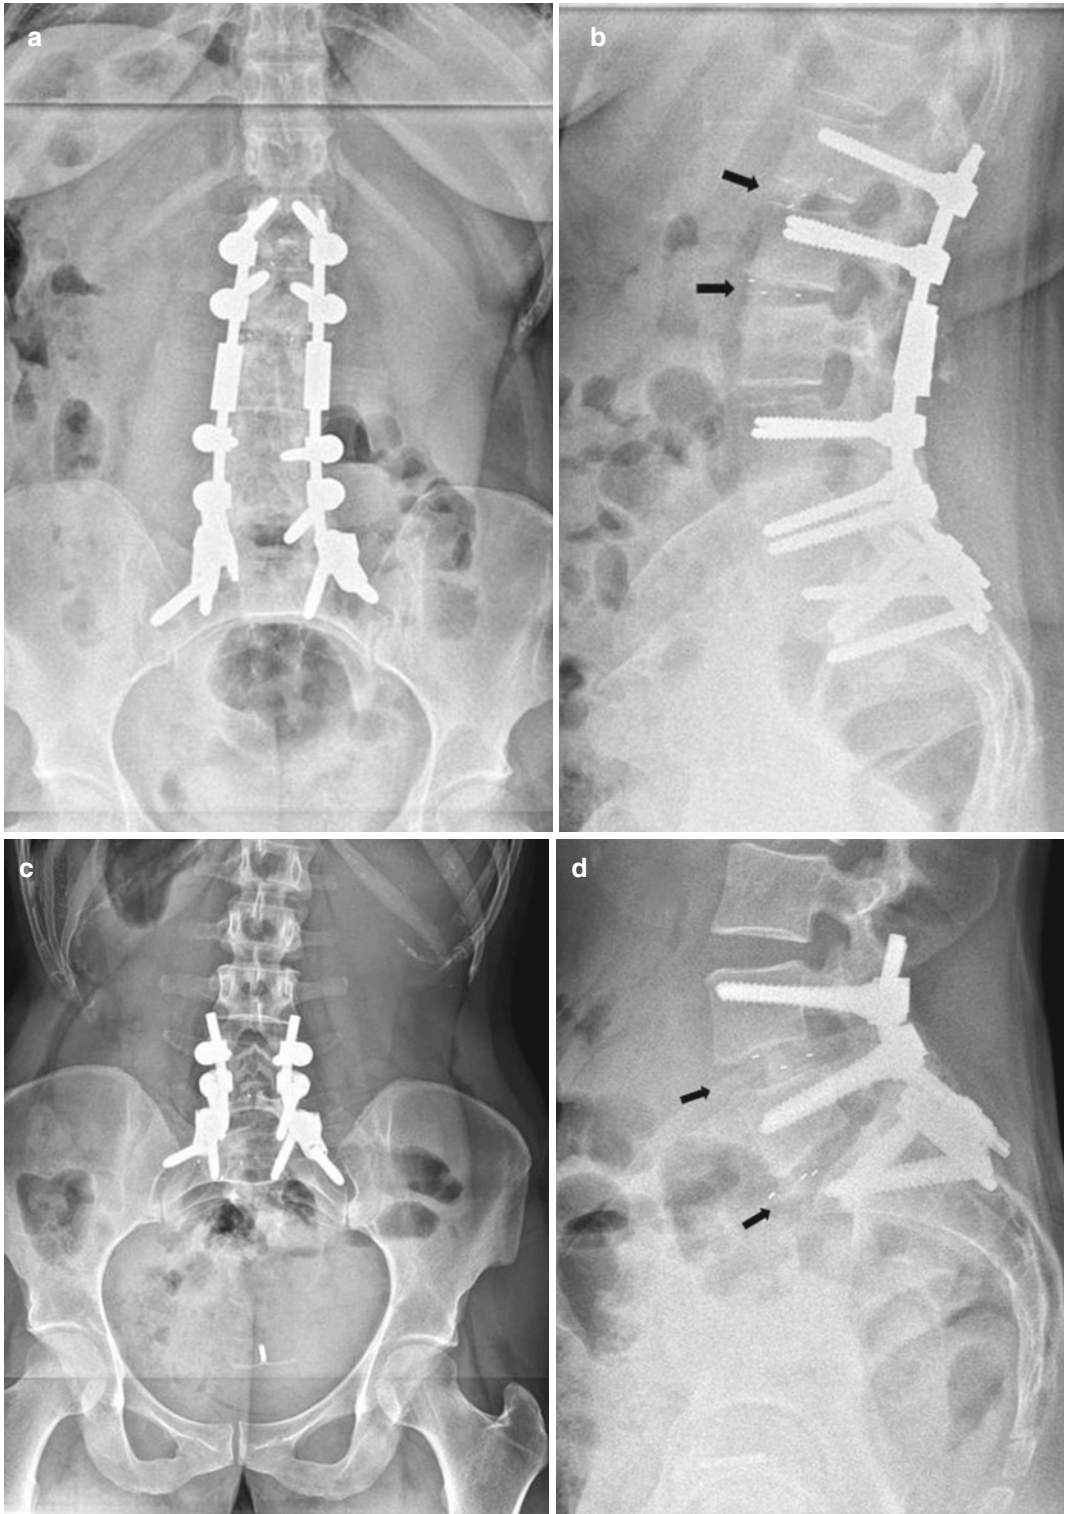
Postoperative radiographs of two different patients undergoing OLIF at L1–L3 (a, b) and L4–S1 (c, d)
